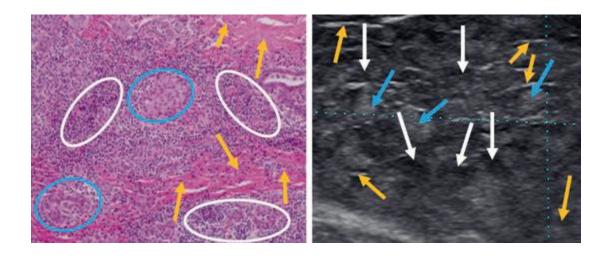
Hashimoto's Thyroiditis Pathology, and Ultrasound Correlation. White circle and white arrows: hypoechoic lymphocytic infiltration. Blue circle and blue arrows: isoechoic thyroid follicular cells. Yellow arrows: hyperechoic fibrotic lines (*16*).
